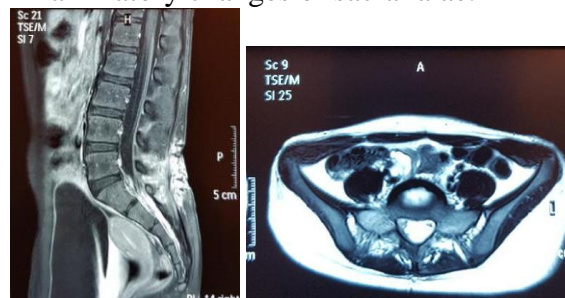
& 2; (MRI Lumbar and Pelvis): shows presacral collection with intraspinal, right paraspinal extension, adjacent right sacral alar osteomyelitis
